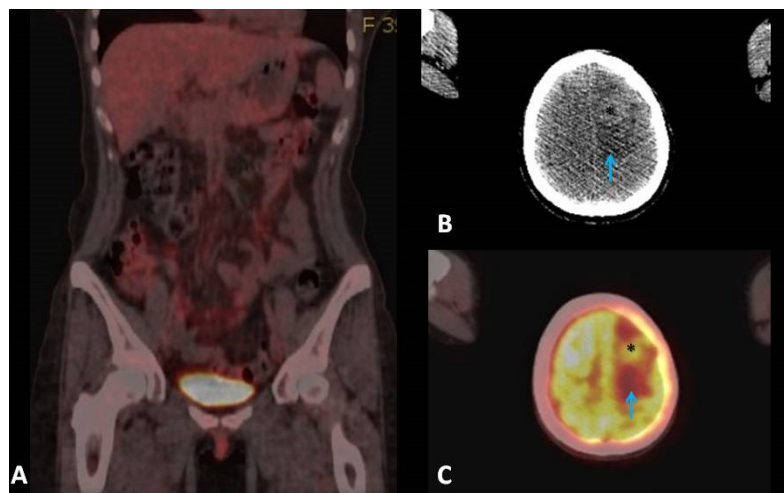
FDG PET-CT findings: The coronal reconstruction (A) showed no signs of relapse or abdominal or pelvic metastases. Cerebral axial reconstruction (B) (C) revealed left frontal vasogenic oedema (blue arrows) surrounding a nodular area suggestive of a cerebral tumour (asterisk).
